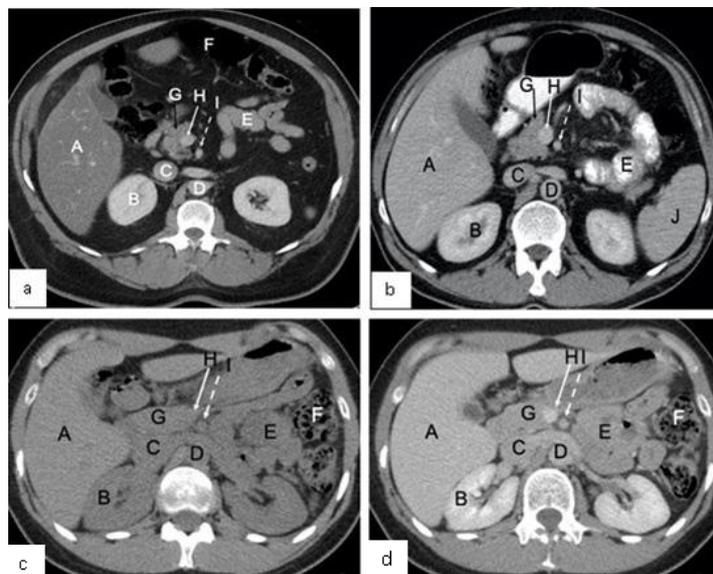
On the axial CT images of the abdomen, identify the normal structures labelled from A to J. Figure 1a and 1b are of two different patients. Figure 1a was acquired after the intravenous administration of radiographic contrast while both intravenous and oral radiographic contrast was given prior to acquisition of Figure 1b. Increased density of small bowel loops in Figure 1b is due to oral contrast.
